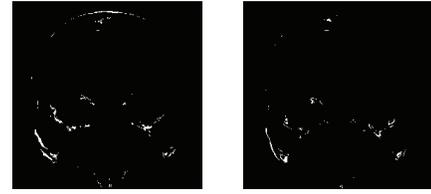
CT and original MRI. (a) unregistered, (b) registered. (Bone only.)
